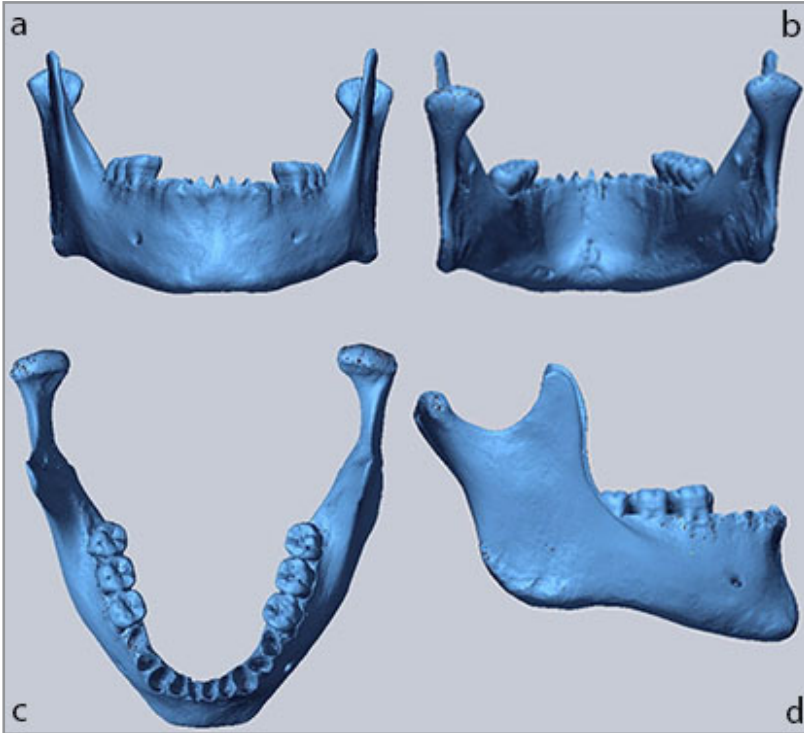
Polygonal model of a dry mandible generated from industrial CT data: a) Anterior view; b) Posterior view; c) Superior view; d) Lateral view
